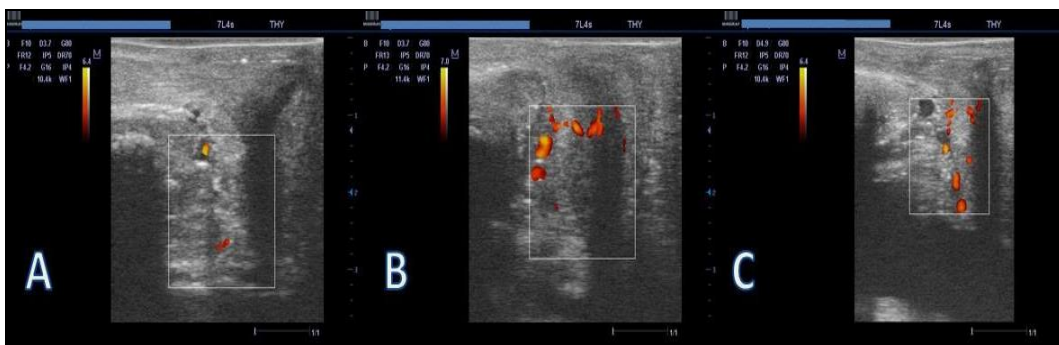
Angio-Doppler at pretreatment (A), post-treatment (B), and one month post-treatment (C).
